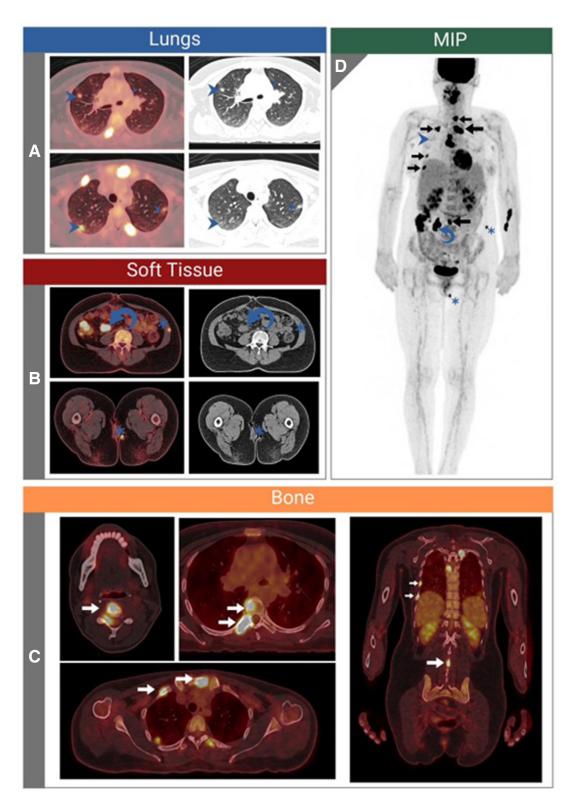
(A) Axial positron emission tomography-computed tomography (PET-CT) and axial CT images demonstrated multiple hypermetabolic pulmonary nodules and ground glass opacities involving both lung fields (blue arrowheads). (B) Axial PET-CT and axial CT images demonstrated a large hypermetabolic abdominal mass lesion occupying the right paramedian region (blue curved arrow) along with evidence of 2 subcutaneous nodules involving the left lateral abdominal wall and left inner thigh (blue asterisk). (C) Axial PET-CT images and coronal PET-CT images demonstrated multiple hypermetabolic lytic bone lesions involving the sternum, right 1st, 7th, and 8th ribs, as well as T6, L3 vertebrae, and the most prominent C4 vertebral body lesion (white arrows). (D) Maximum intensity projection image demonstrated a hypermetabolic process involving bilateral pulmonary nodules (blue arrowheads), abdominal mass lesion (blue curved arrow), 2 skin nodules (blue asterisk), and multiple lytic bone lesions (black arrows). The overall picture was potentially suspicious, necessitating tissue confirmation by biopsy to exclude malignant pathology.
